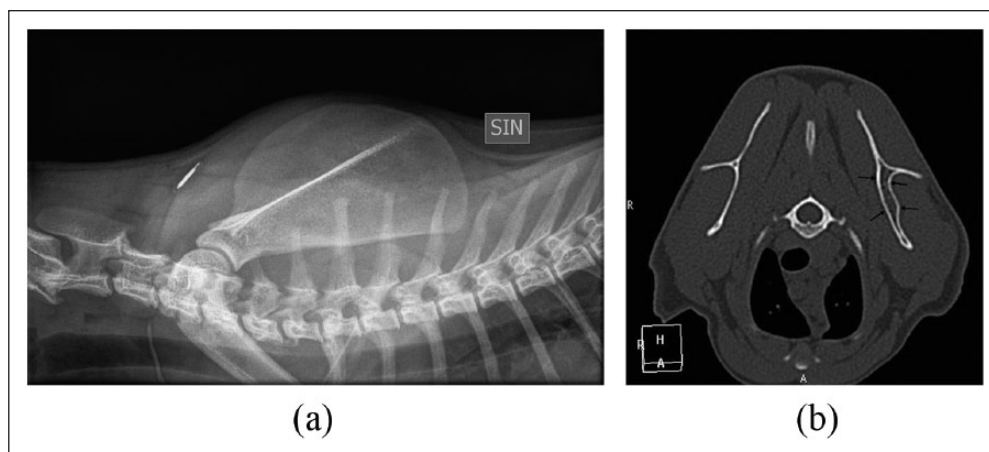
(a) Twenty-week follow-up mediolateral projection of the left scapula. The lesion is no longer detectable. A microchip has been implanted subcutaneously in the neck. (b) Follow-up transverse CT image (window level 500, window width 2000, slice thickness 1.0 mm). There is mild expansion of the left scapula with smoothly outlined cortex without periosteal reaction
